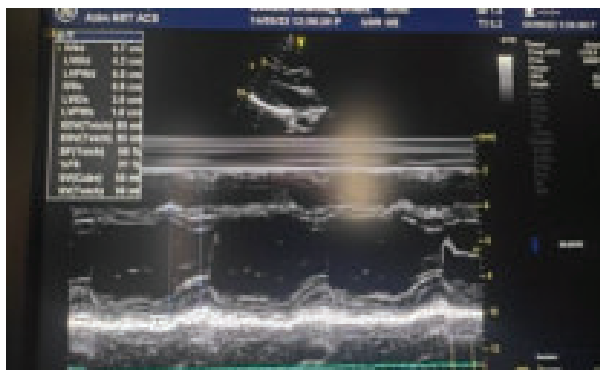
Echocardiography: No RWMA, EF 59%.
